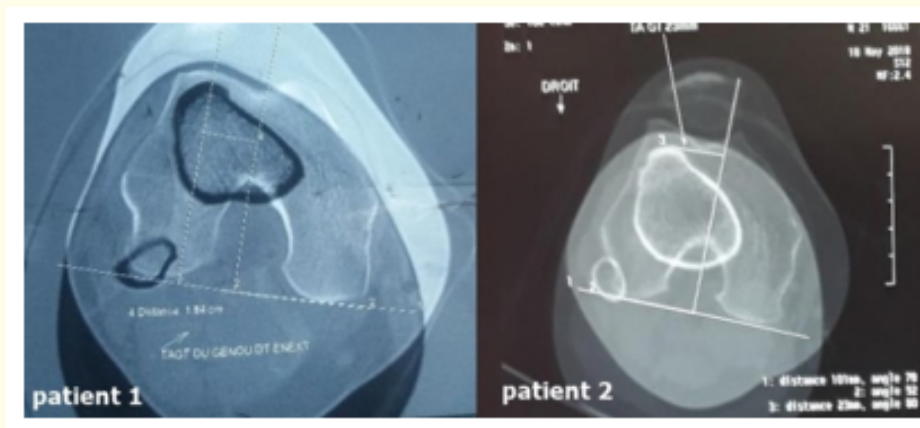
CT-scan images showing increasing TA-GT distance of both patients.
